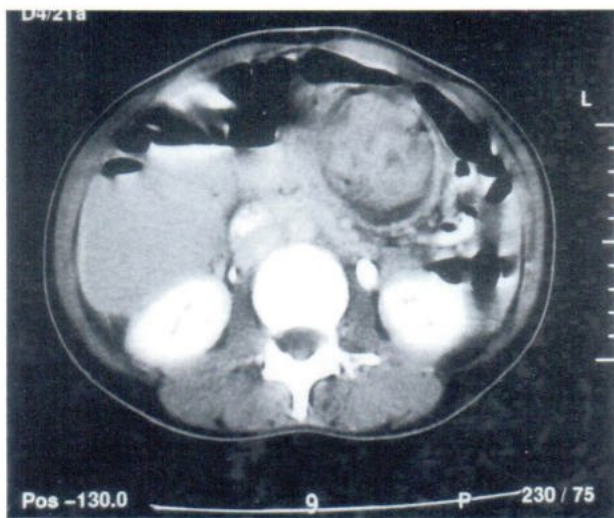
Axial CT scan shows bowel in bowel appearance with mesenteric fat being drawn into the intussusception.
